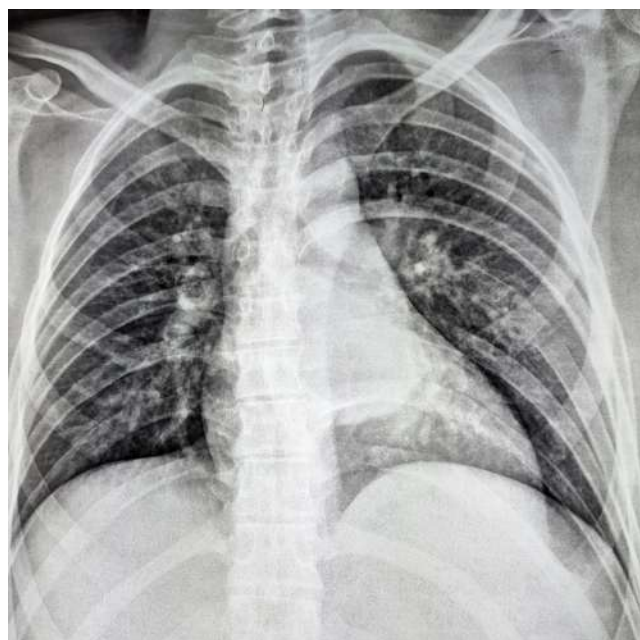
Chest X-ray showing posterior mediastinal opacity in relation to costovertebral hydatid cyst
